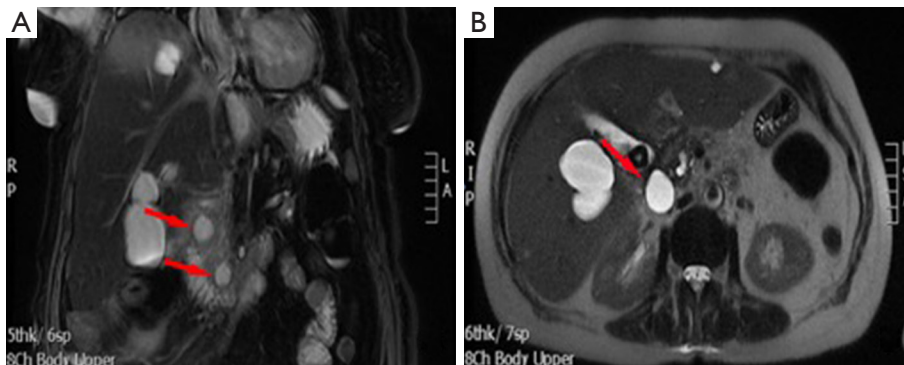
Pseudocyst (red arrows) in unenhanced coronal and axial magnetic resonance T2-w images with (A) and without (B) fat suppression. T2-w, T2-weighted.
